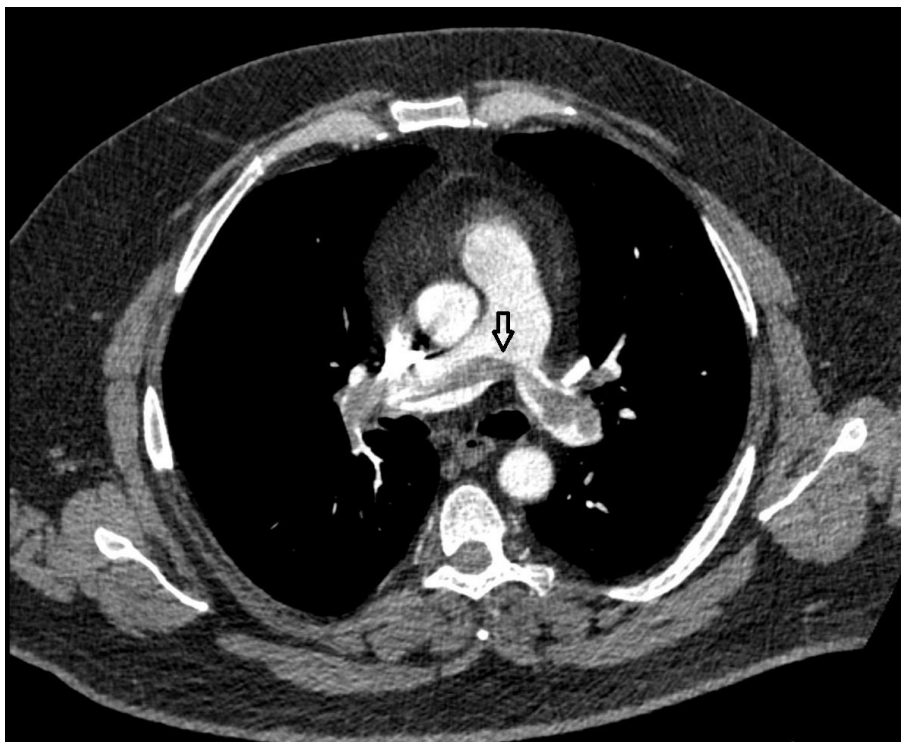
Computed Tomography Pulmonary Angiogram
